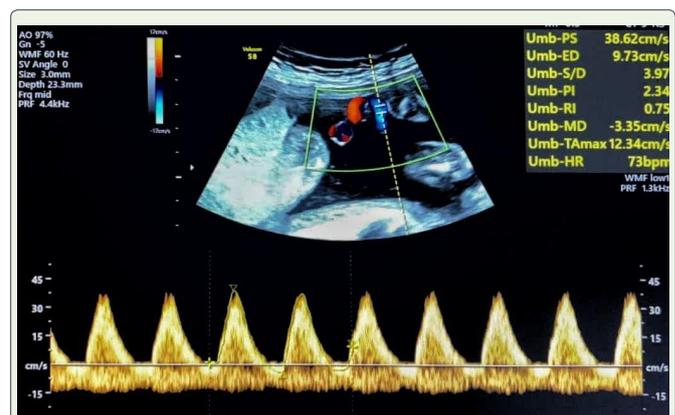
Umbilical artery doppler at 38 weeks of pregnancy shows reversed end-diastolic flow.
